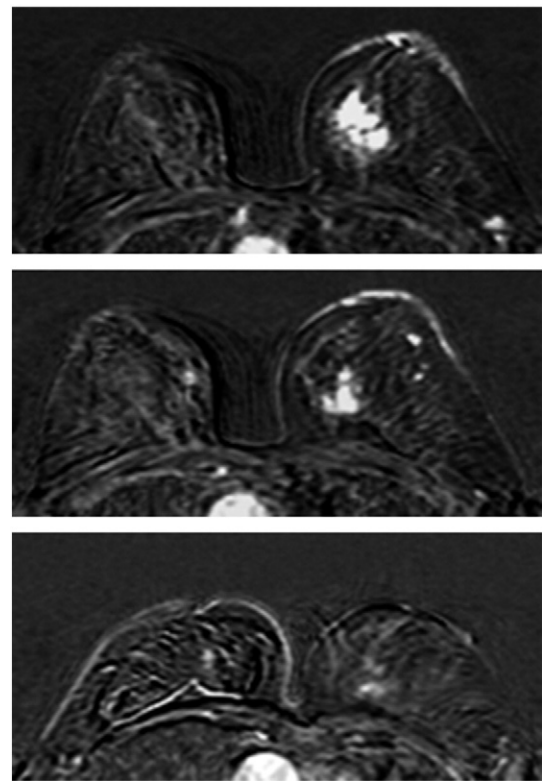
Contrast-enhanced subtraction images of a 56-year-old woman with non-pCR after NAC. Before NAC, a 3-cm ER-positive and HER2-negative IDC in the left breast was noted. Upper panel: baseline MRI; middle panel: FU-1 MRI (after two AC); lower panel: FU-2 MRI (after two AC plus three AbCaH). Note that the background enhancement in the fibroglandular tissue of the right breast throughout the three MRI studies was scarce.
